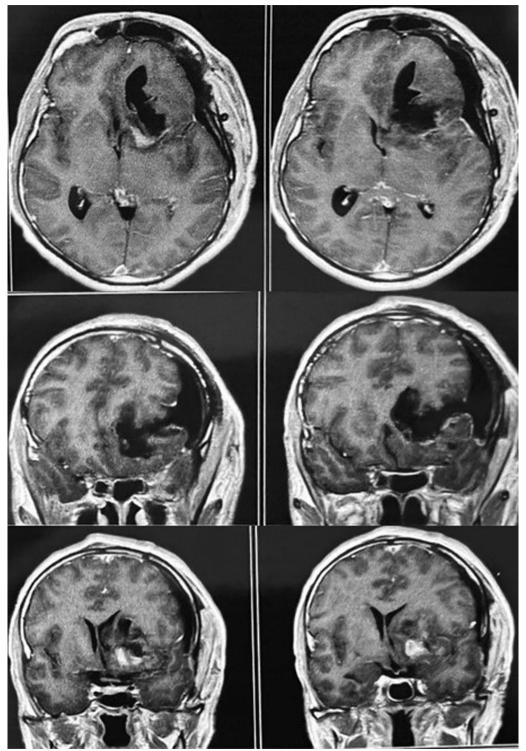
Postoperative MRI images showing near total excision of the tumor
